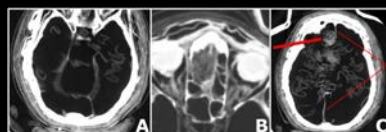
CT scan of Djedmaatesankh, showing (A) dural partitions, (B) damaged ethmoid air cells, (C) a nasal tampon (thick line), and the severed falx cerebri (thin lines) crossed by linen packing.
